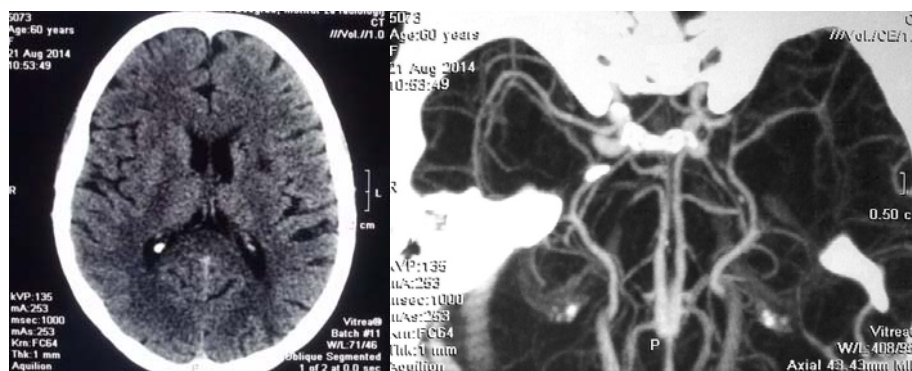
Repeated multislice computed tomography (MSCT) and MSCT angiography showing M2 and M3 postcontrast opacification of left medial cerebral artery (MCA).
